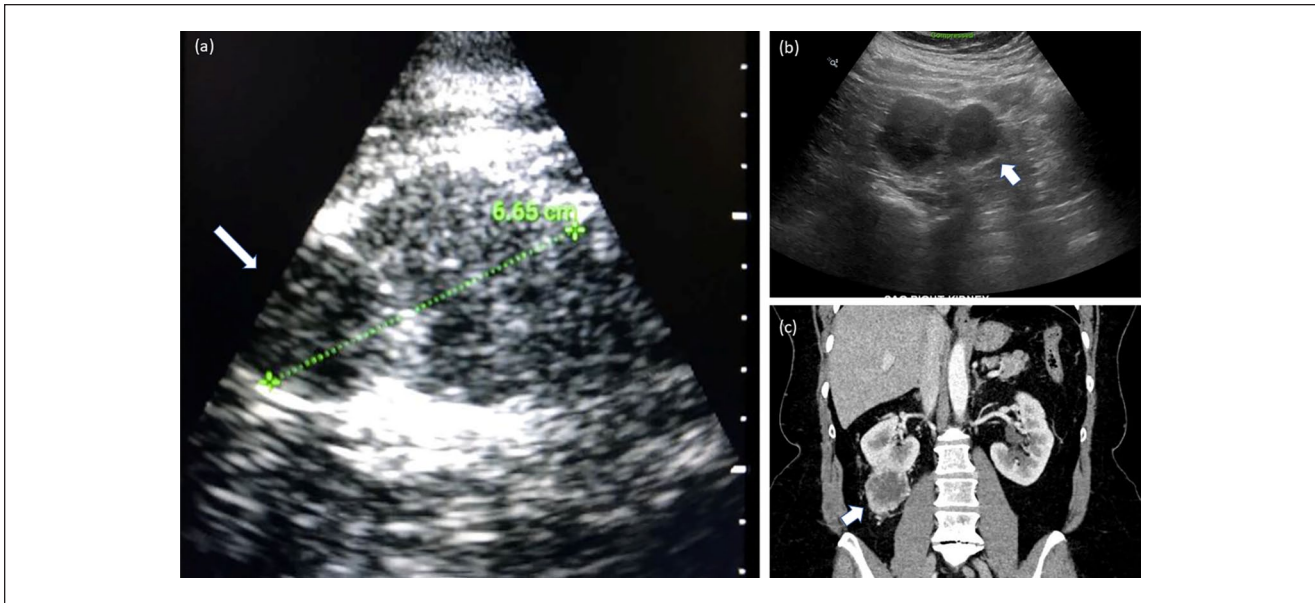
(a) Point-of-care ultrasound image of the right kidney in an asymptomatic 54-year-old woman shows a peripherally located isoechoic solid mass (arrow) causing distortion of the renal border. (b) Formal renal ultrasonography image of 1 (arrow) of 2 solid masses found in the inferior pole of the right kidney, the largest measuring 4.6 cm in its biggest dimension. (c) Contrast-enhanced computed tomography imaging of the abdomen and pelvis, coronal view shows a peripheral, likely multifocal renal cell carcinoma (arrow) in the inferior pole of the right kidney.
